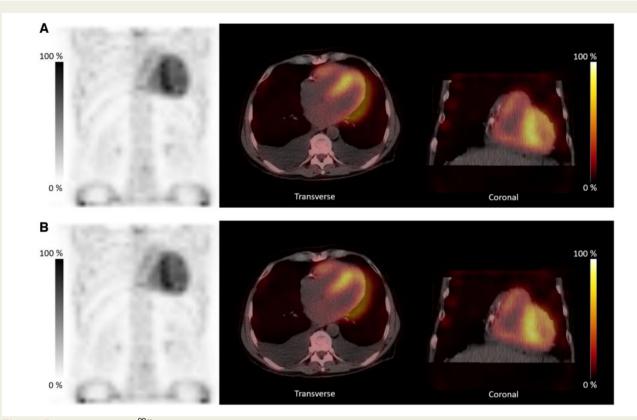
Bone scintigraphy (<sup>99m</sup>Technecium-DPD) with HCL ratio of >1.5 and Grade 3 according to the Perugini grading system.
